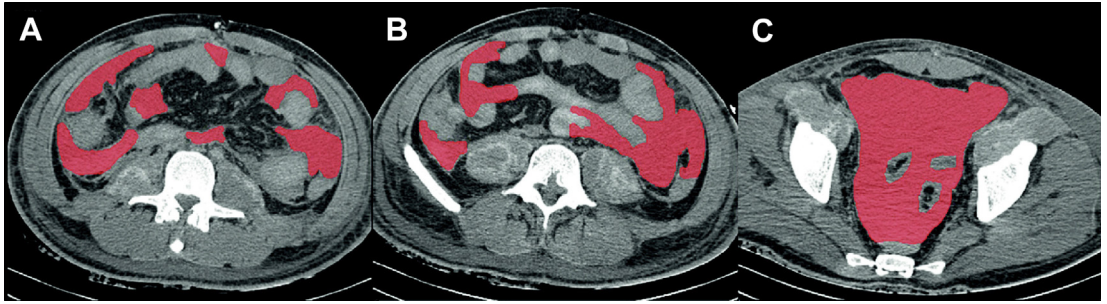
Axial CT images of the abdomen at 3 distinct levels (A–C). The free abdominal blood is manually marked during segmentation (*red colored areas*). (From Ampanozi G, Hatch GM, Ruder TD, et al. Post-mortem virtual estimation of free abdominal blood volume. *Eur J Radiol* 2011;81:2134; with permission.)
